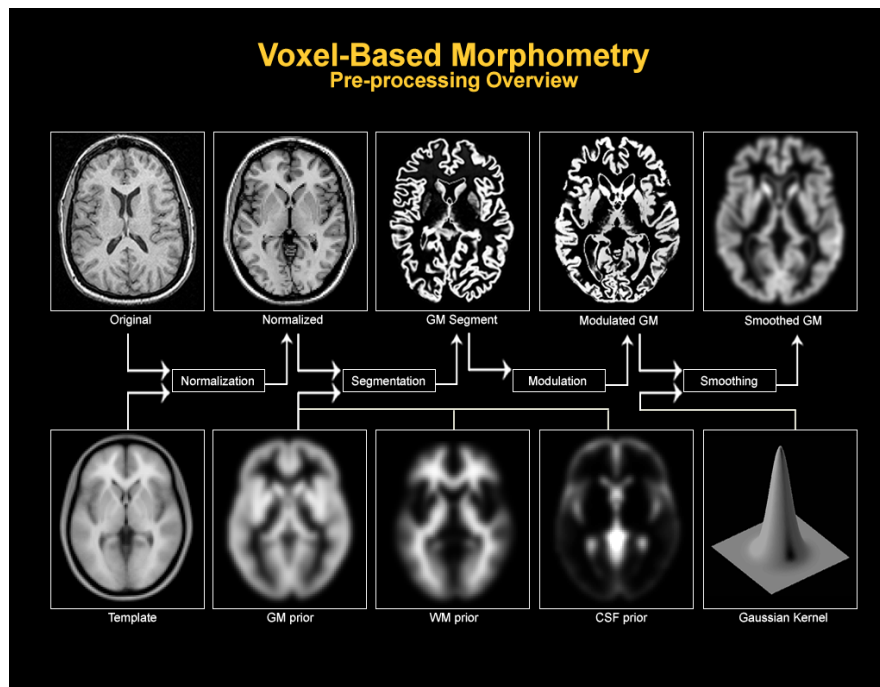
[46] See appendix I for larger display. This chart demonstrates the stages of VBM, starting from an original MR image to a smoothed image ready for statistical analysis.
